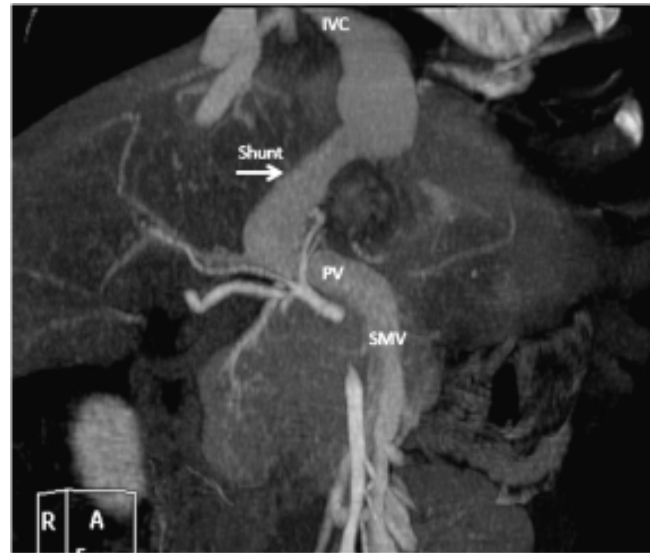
CT angiography of case 2 shows a congenital portosystemic shunt (arrow) arising from the left portal vein and diverting the flow to the inferior vena cava/right atrium. IVC: Inferior vena cava. PV: Portal vein. SMV: Superior mesenteric vein.
